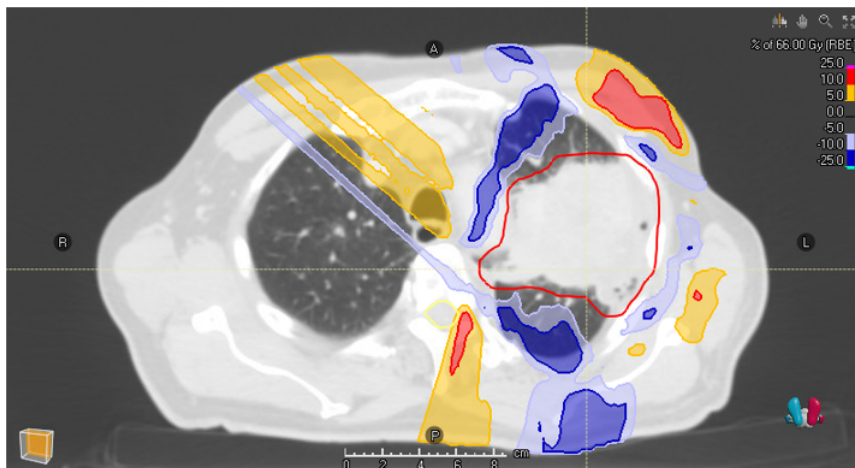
Difference in dose distribution in a single CT 1 slice for patient 9. Dose delivered with IMPT_{3%} is subtracted from dose delivered with IMPT_{4.5%}. The map shows higher dose near the spinal cord (yellow circle) in the IMPT_{4.5%} plan.
